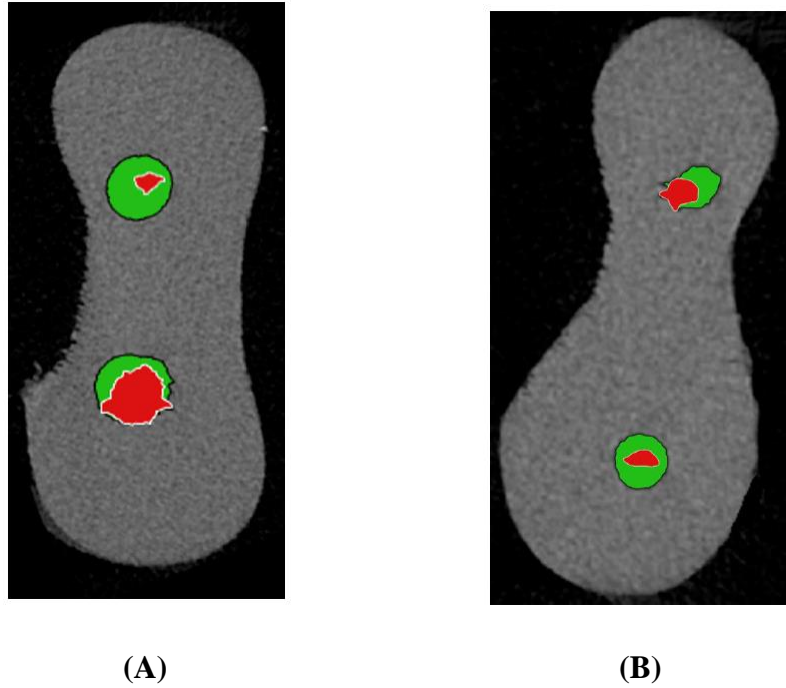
Micro CT images of samples from different levels (red: preinstrumented canal; green: post-instrumented canal with rotary file); (A) Coronal level using PTG; (B) Apical level using WOG
